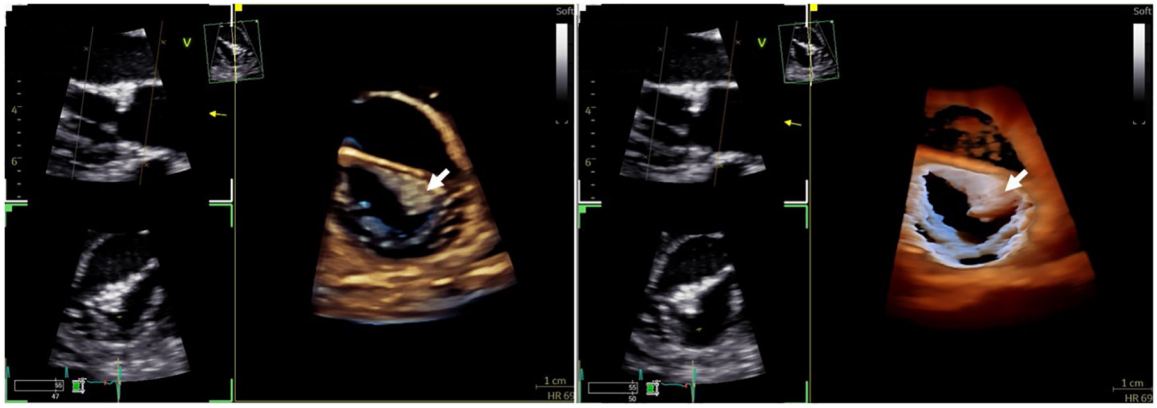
3D Transthoracic Echocardiography of the Mitral Valve With Transillumination
